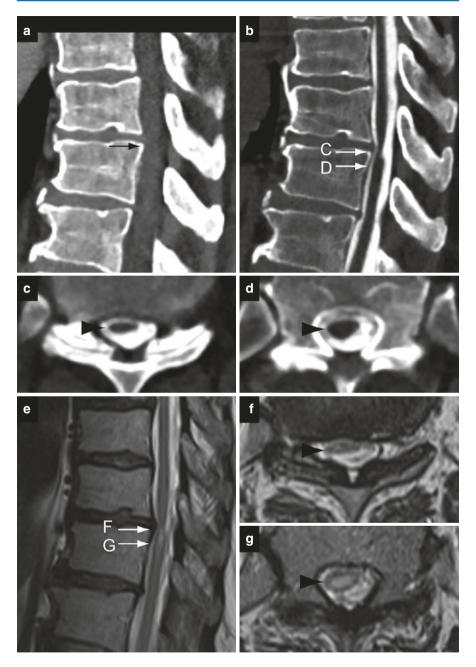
Multimodality imaging of a patient with intrathecal adhesions deforming the spinal cord. (a) Intravenous contrast enhanced CT is unable to discern the spinal cord from the CSF in the thecal sac and does not demonstrate an apparent abnormality at the level of T10–11 disc space (arrow). (b–d) CT myelogram demonstrates focal anterior displacement and deformity of the spinal cord outlined by high attenuation intrathecal contrast. Axial images confirm focal deformity of the spinal cord (black arrowhead) in the anterior-posterior direction (c) compared to a more normal appearing level more caudally (d). (e–g) T2W MR images demonstrate increased T2 signal in the spinal cord at the level of the T10–11 disc space (f) that extends inferiorly for a short distance (g)
